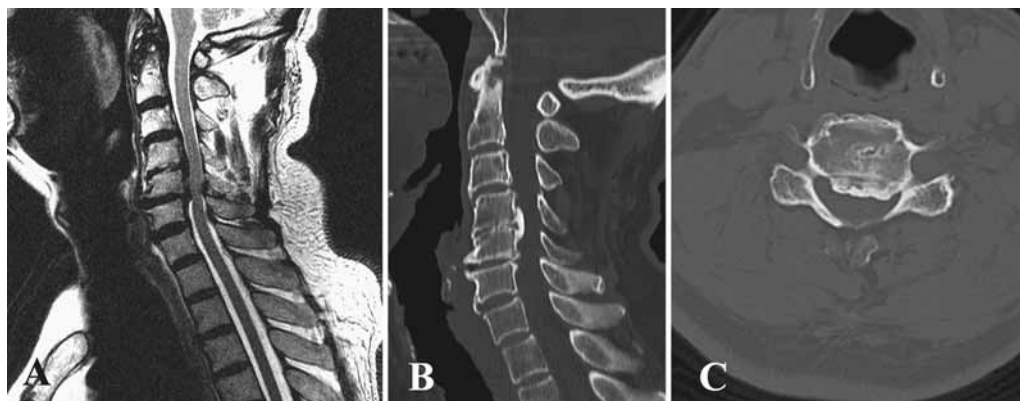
Case 4. Preoperative images. This 79-year-old man with gait difficulties was found to have cervical spondylitic myelopathy secondary to continuous OPLL as seen on sagittal T2-weighted MR imaging (A), sagittal CT reconstruction (B), and axial CT (C).
